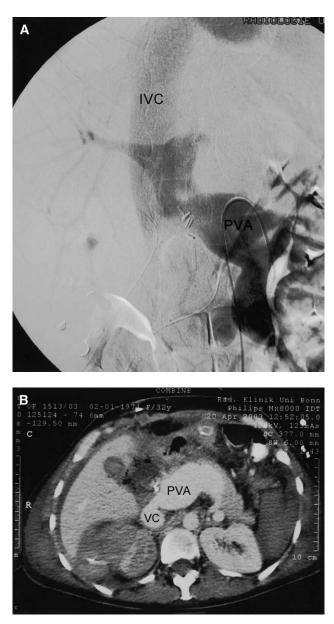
Postoperative imaging on day 5 after the operation. A, Indirect splenoportography depicts the patency of the portal system with orthograde flow into the liver and patency of the portocaval shunt by opacification of the inferior vena cava (VC). B, Helical computed tomography scan with contrast enhancement of the portal venous phase showing the still enlarged portal vein (PVA) and the patency of the portocaval shunt as evidenced by contrast media in the inferior VC.
